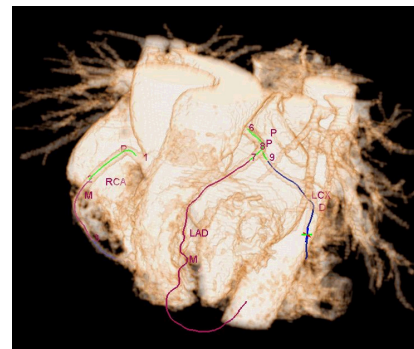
A screenshot of our vessel parsing system using CTA volume.
